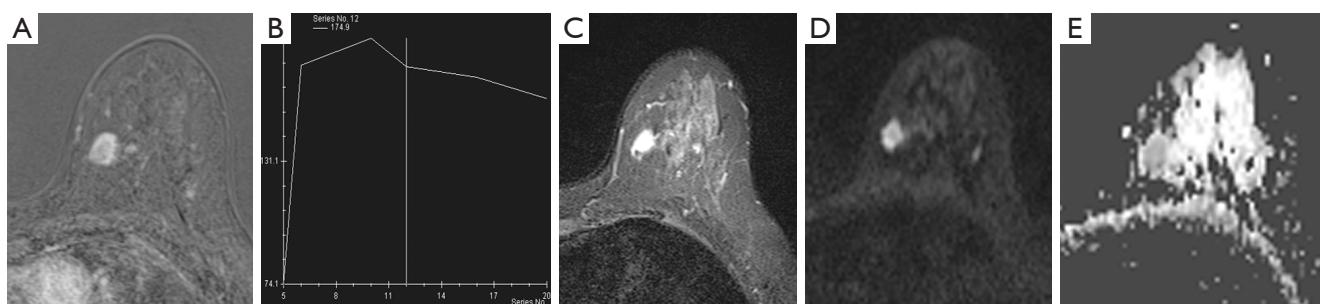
A 53-year-old woman presented with a mass in the left breast on MRI which was classified as BI-RADS 4 category. (A,B) The mass demonstrated oval shape, spiculated margin, rim enhancement and washout kinetics. (C,D) The lesion showed high signal intensity on both T2WI and DWI, with absence of edema. (E) ADC value was $0.911 \times 10^{-3} \text{ mm}^2/\text{s}$. The lesion was considered malignant by Kaiser score and the three mpMRI-based decision rules. Pathology showed invasive ductal carcinoma. MRI, magnetic resonance imaging; BI-RADS, breast imaging reporting and data system; T2WI, T2-weighted imaging; DWI, diffusion-weighted imaging; ADC, apparent diffusion coefficient; mpMRI, multiparametric magnetic resonance imaging.
